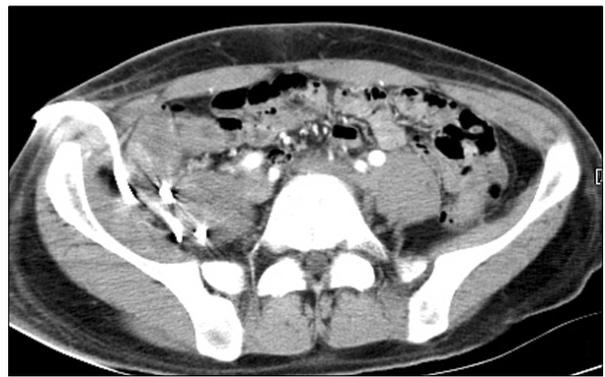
Contrast-enhanced abdominal CT scans showing that the right psoas-iliacus abscess is almost resolved with CT-guided percutaneous drainage.
